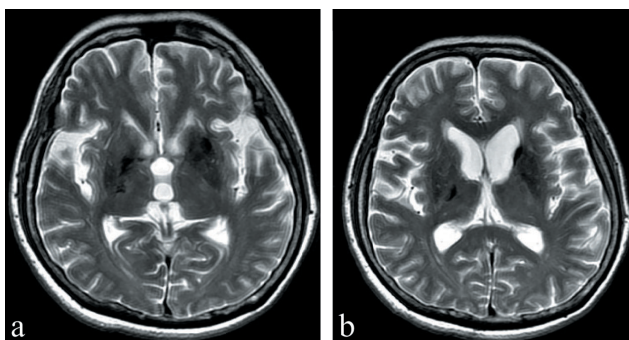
T2-weighted images of brain magnetic resonance imaging study. Figure 4a (July 23th, 2008) and Figure 4b (February 12th, 2009) show progressive resolution of previous lesions.
